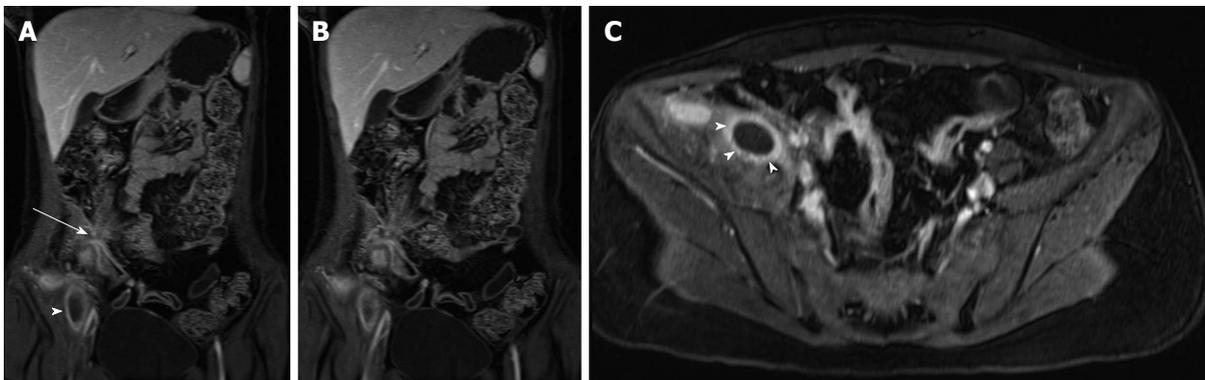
Active distal ileal Crohn's disease with complex fistulization and iliopsoas abscess formation. A and B: Coronal; C: Axial fat-suppressed post-gadolinium 3D-GRE T1-weighted images. There is evidence of terminal ileal thickening and enhancement in keeping with active Crohn's disease, associated with complex ileoileal and ileosigmoidal fistula formation (star sign, arrow, A and B) as well as iliopsoas inflammation and abscess formation (arrowheads, A, B and C). GRE: Gradient recalled echo.
